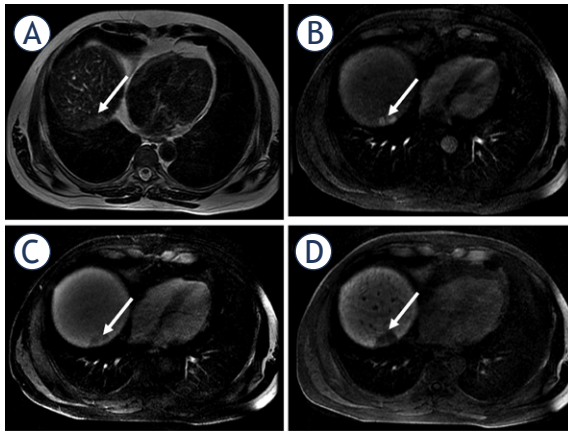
49-year-old woman with cirrhosis due to chronic hepatitis C had a new hepatic nodule detected on screening ultrasound which was confirmed as HCC on MRI with hepatobiliary contrast agent. Hepatic nodule in segment VII (arrows) with high signal intensity on T2 weighted image (T2WI) (A), hyperenhancement in the late arterial phase (B), washout appearance (C), and hypointense appearance in the hepatobiliary phase.
